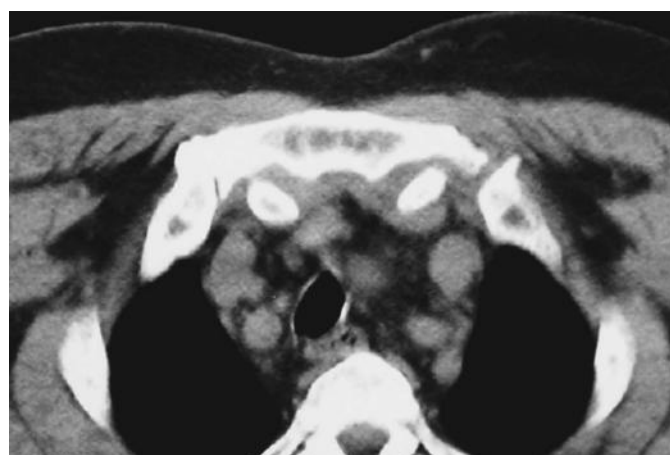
(axial CT scan, twelve months later): Slight dilation of the first sternocostal junction due the presence of a very small soft mass.
